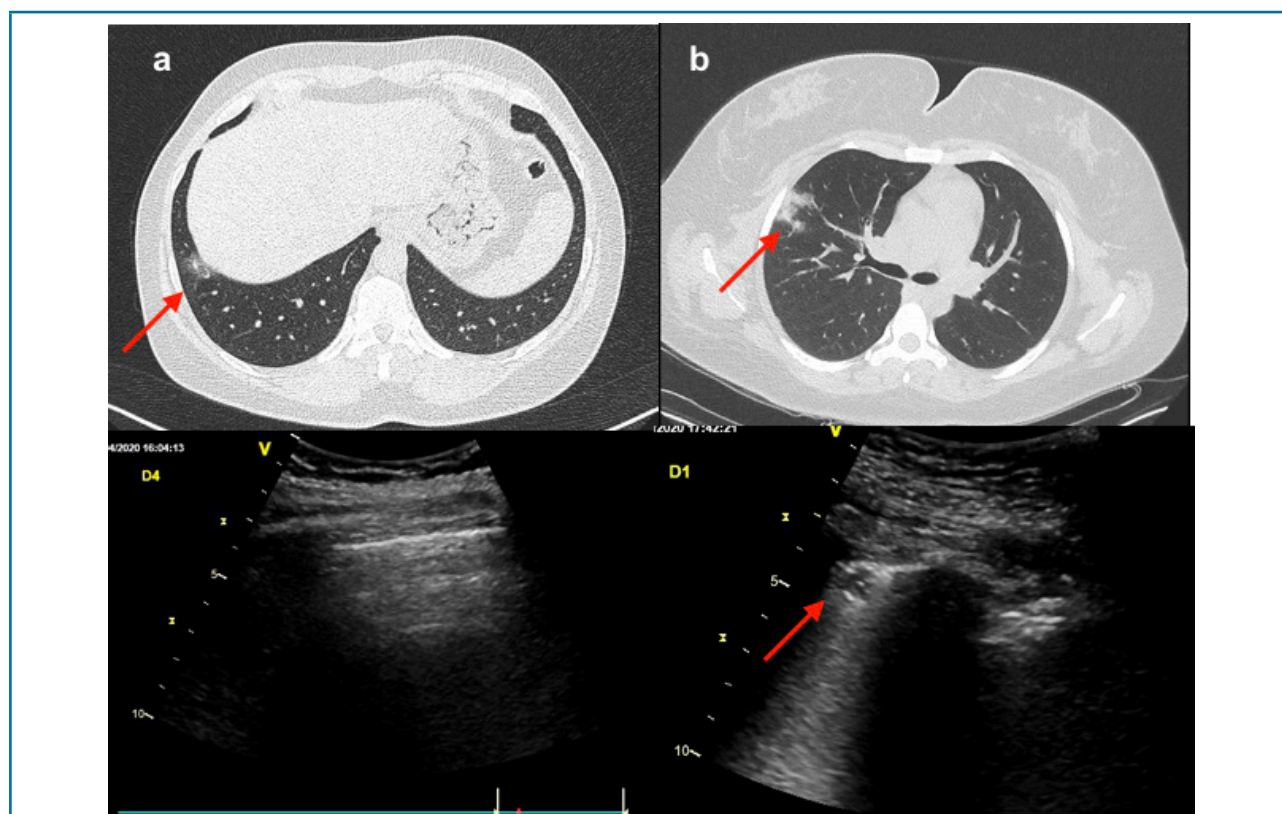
Representative CT and corresponding LUS images of 2 patients with minor pulmonary involvement. Case (a) was a 42-year-old female with a deep lesion in the lung and a normal A line profile on LUS. Case (b) was a 27 year old female with subpleural consolidation, also demonstrated on LUS (red arrow), as well as coalescent B-lines
